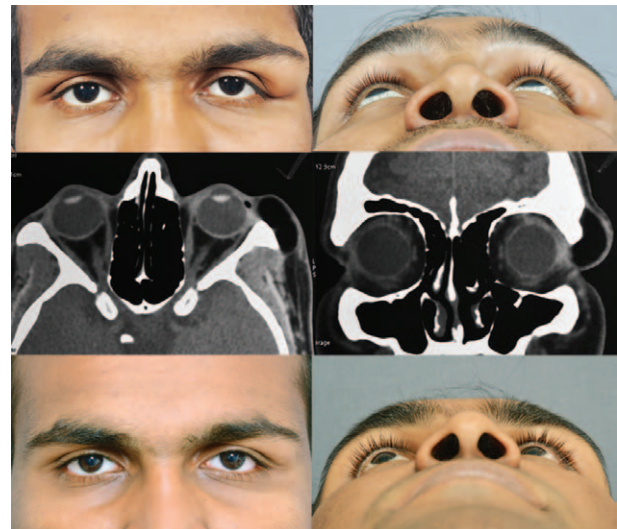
Case 2: A 22-year-old man with left lateral orbitotemporal cystic swelling with bony fixity (top). CT scan of the orbit showed a well-defined cystic mass extending over the lateral orbital rim into the temporal fossa (centre) along with bony fossa formation. Same patient 9 months following foam sclerotherapy (2 sessions 3 months apart), showing complete resolution of the dermoid cyst (bottom).
